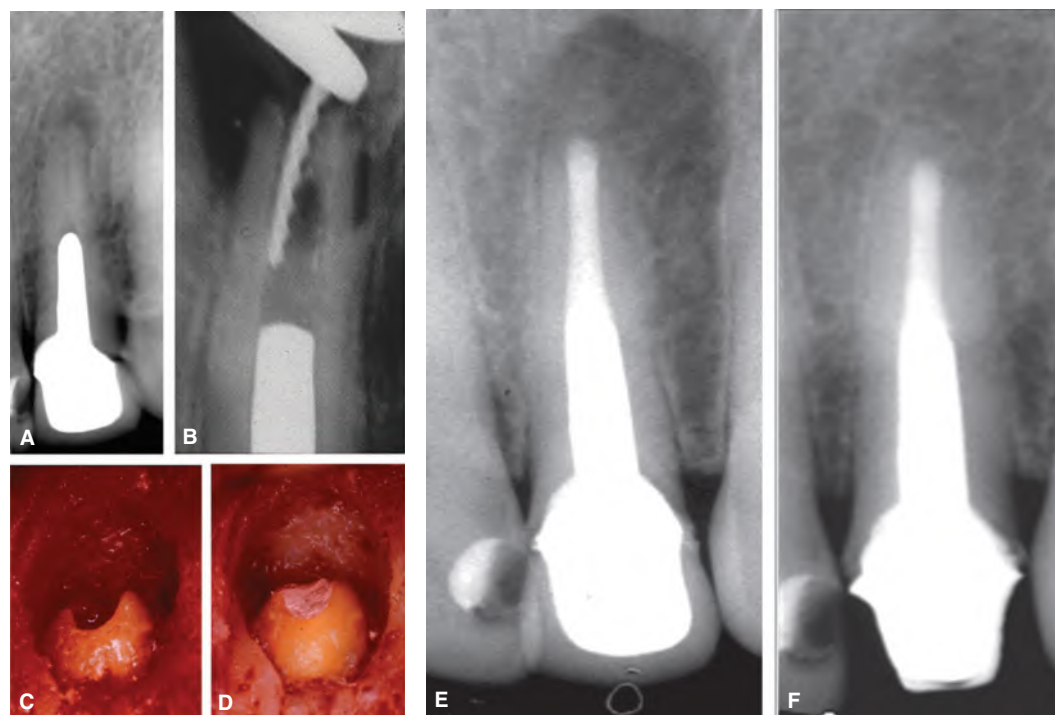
Surgical endodontic retreatment in a maxillary lateral incisor of a 38-year-old female. A. Preoperative radiograph showing a periapical radiolucency associated with the tooth. A large post and a crown are present. There is no evidence that the remaining root canal space was treated. The patient reported intermittent symptoms associated with this tooth. A decision was made to keep the post in place, reflect a buccal flap, and approach the remainder of the root canal space from the apical end. B. Radiograph showing endodontic instrument inserted from the apex. C. Clinical photograph following instrumentation of the root canal space. D. Clinical photograph following retro-obturation of the root canal space with thermoplasticized gutta-percha and sealer. E. Immediate postoperative radiograph. The root canal space was retro-obtured to the post level. F. 17-year follow-up radiograph. The periapical radiolucency has resolved and the patient is asymptomatic.
